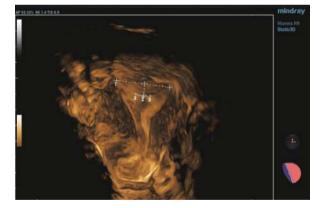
Coronal view of a completely septated uterus with a gestation sac visible in the right uterine cavity on 3D ultrasound
